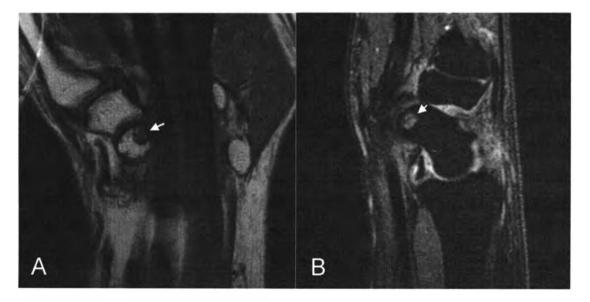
Case 1 right wrist MR images.
